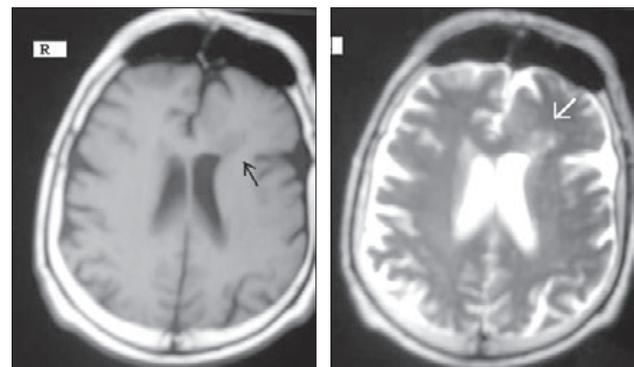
Axial T1(a) and T2(b)-weighted MRI of patient with focal cortical dysplasia in the left frontal cortex.
